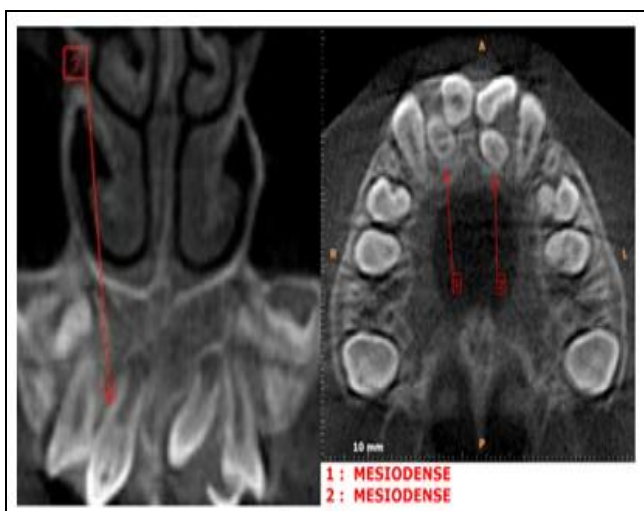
CBCT Showing Mesiodens Present Palatal to 11, Showed Central Radiolucency and somewhat oval Radiopacity which was giving the Appearance of Tooth within Tooth Indicative of Dens Invaginatus
